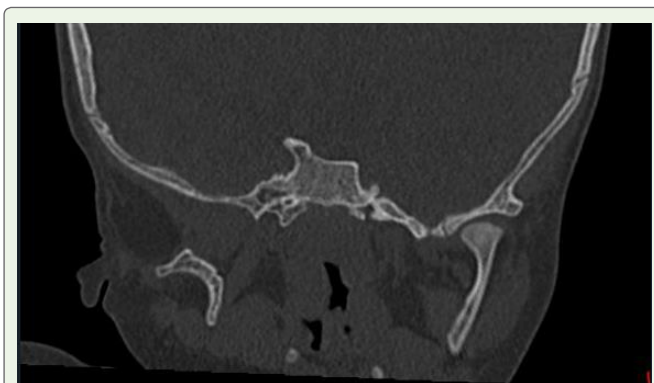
Sagittal MPR reconstructed section CT temporal bone shows absent or dysplastic right mandibular condyle.
